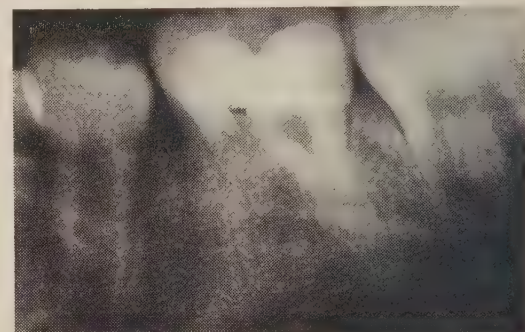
Radiograph showing a lower first permanent molar with a double mesial root and a third lingual root.
